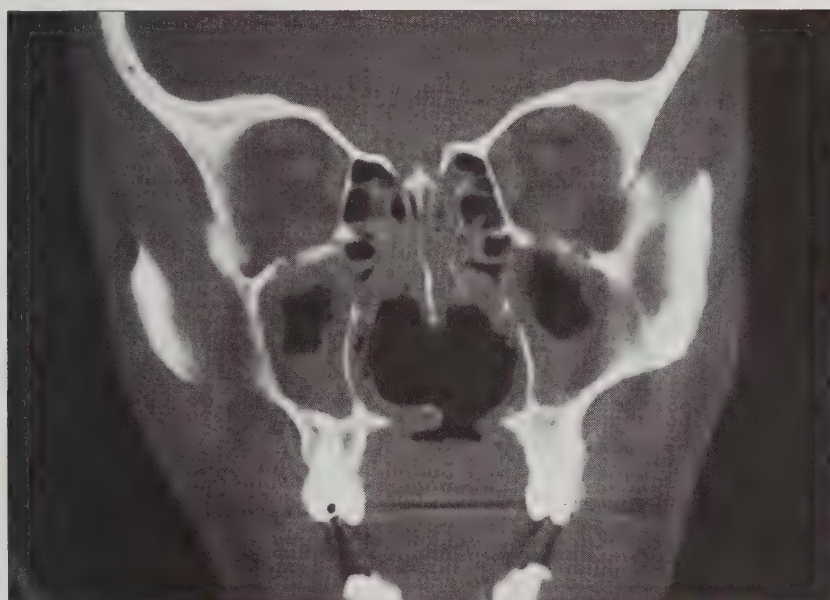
CT scan showing palatal perforation, loss of nasal septum and turbinates, and thickening of the maxillary sinus membranes.
